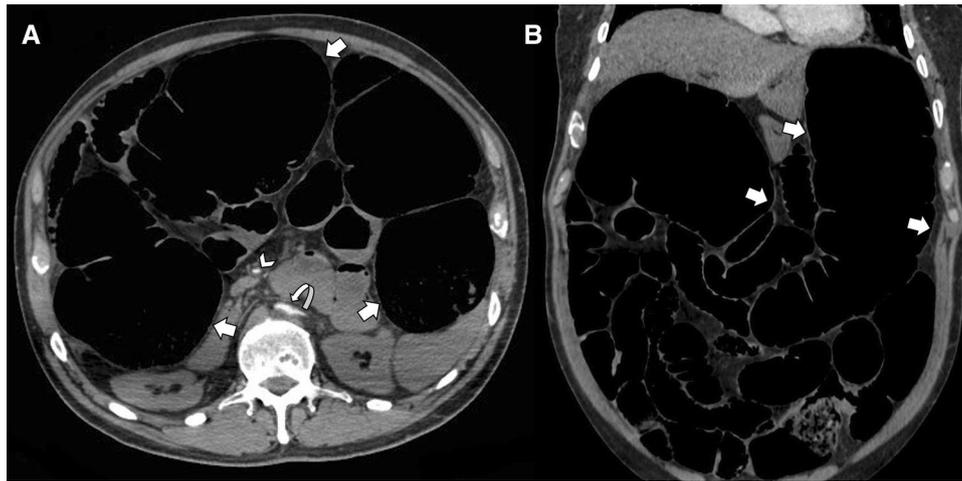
Acute mesenteric ischemia in a 59-year-old man. a Axial contrast-enhanced CT image shows extremely dilated and gas-filled bowel loops, with thinning of small and large bowel wall (arrows), producing the characteristic “paper-thin wall” appearance. The diameter of abdominal aorta is significantly decreased (curved arrow) due
